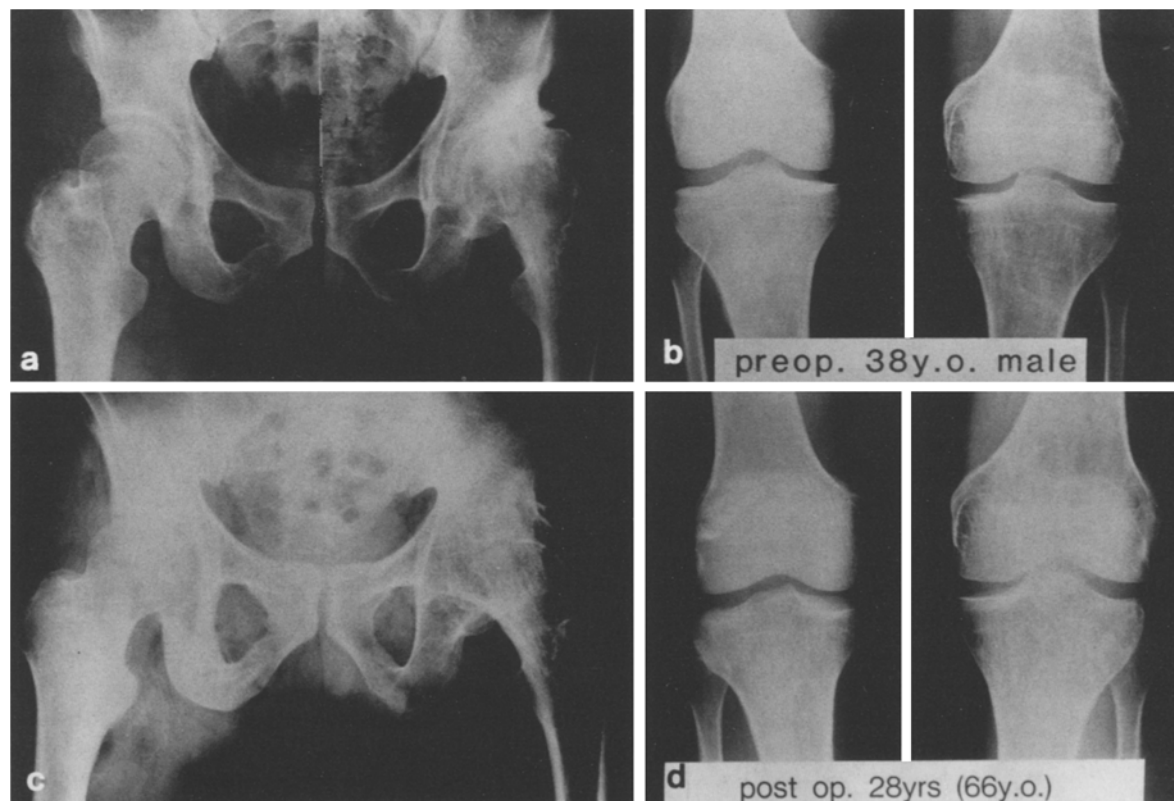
a–d. Radiographs of a 38 year old man before arthrodesis (a, b). 28 years after arthrodesis, both knees and the opposite hip remain normal (c, d)
